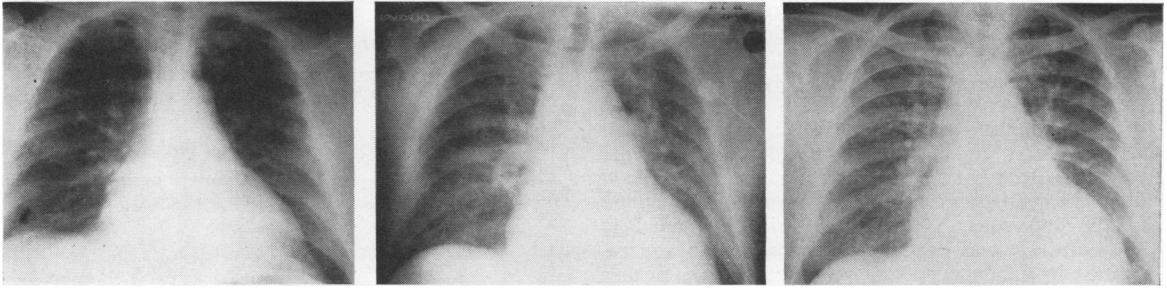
Chest radiographs prior to operation: (a) three days after the infarction on the day he developed sudden dyspnoea and a pansystolic murmur; (b) three days after cardiac arrest; (c) three months after rupture of the ventricular septum. In gross congestive heart failure.
